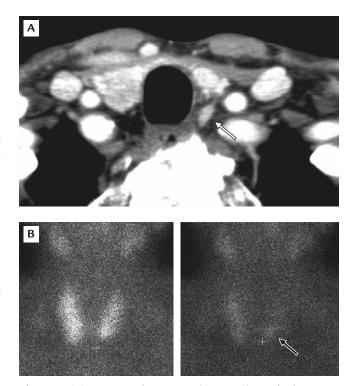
(A) Computed tomography scan showed a homogeneous, enhancing mass (arrow) posterior to the left lobe of the thyroid gland. (B) MIBI scintigraphy. Early-phase (left panel) and delayed-phase (right panel) scintigrams show a focus of uptake in inferior aspect of the left thyroid lobe (arrow).
